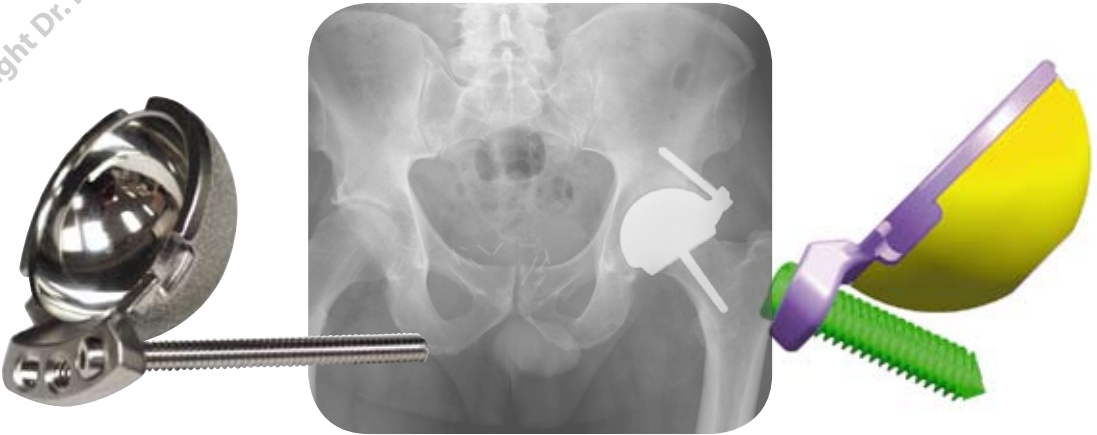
Quadrafix Conserve Plus cup. Implant with flange and one screw, x-ray of an implant and a CAD picture showing the 20 degree angle of the screws. Quadrafix cups are available in 2 mm increments.
